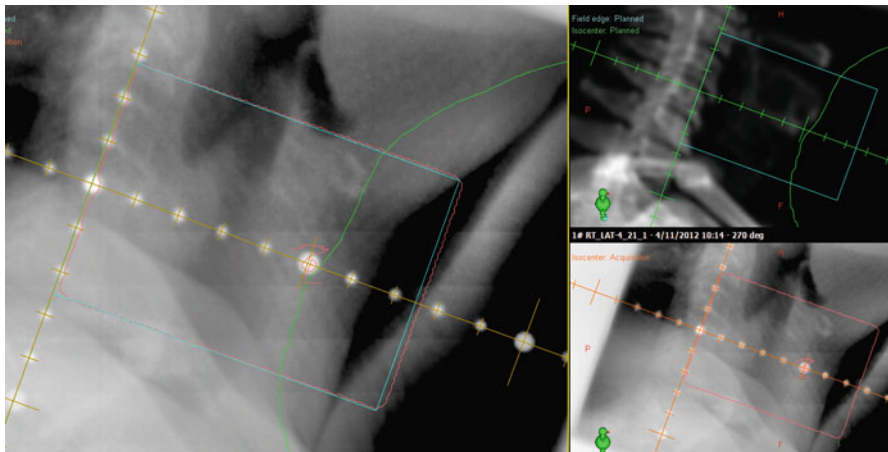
displays the daily verification of treatment using electronic portal imager (EPID). The EPID image is the lower right corner and the digitally constructed image (DRR) from CT images shown on the upper right corner. Both images are co-registered and displayed on the right window demonstrating a good setup with a very minimal error in positioning using the patient's bony anatomy.
